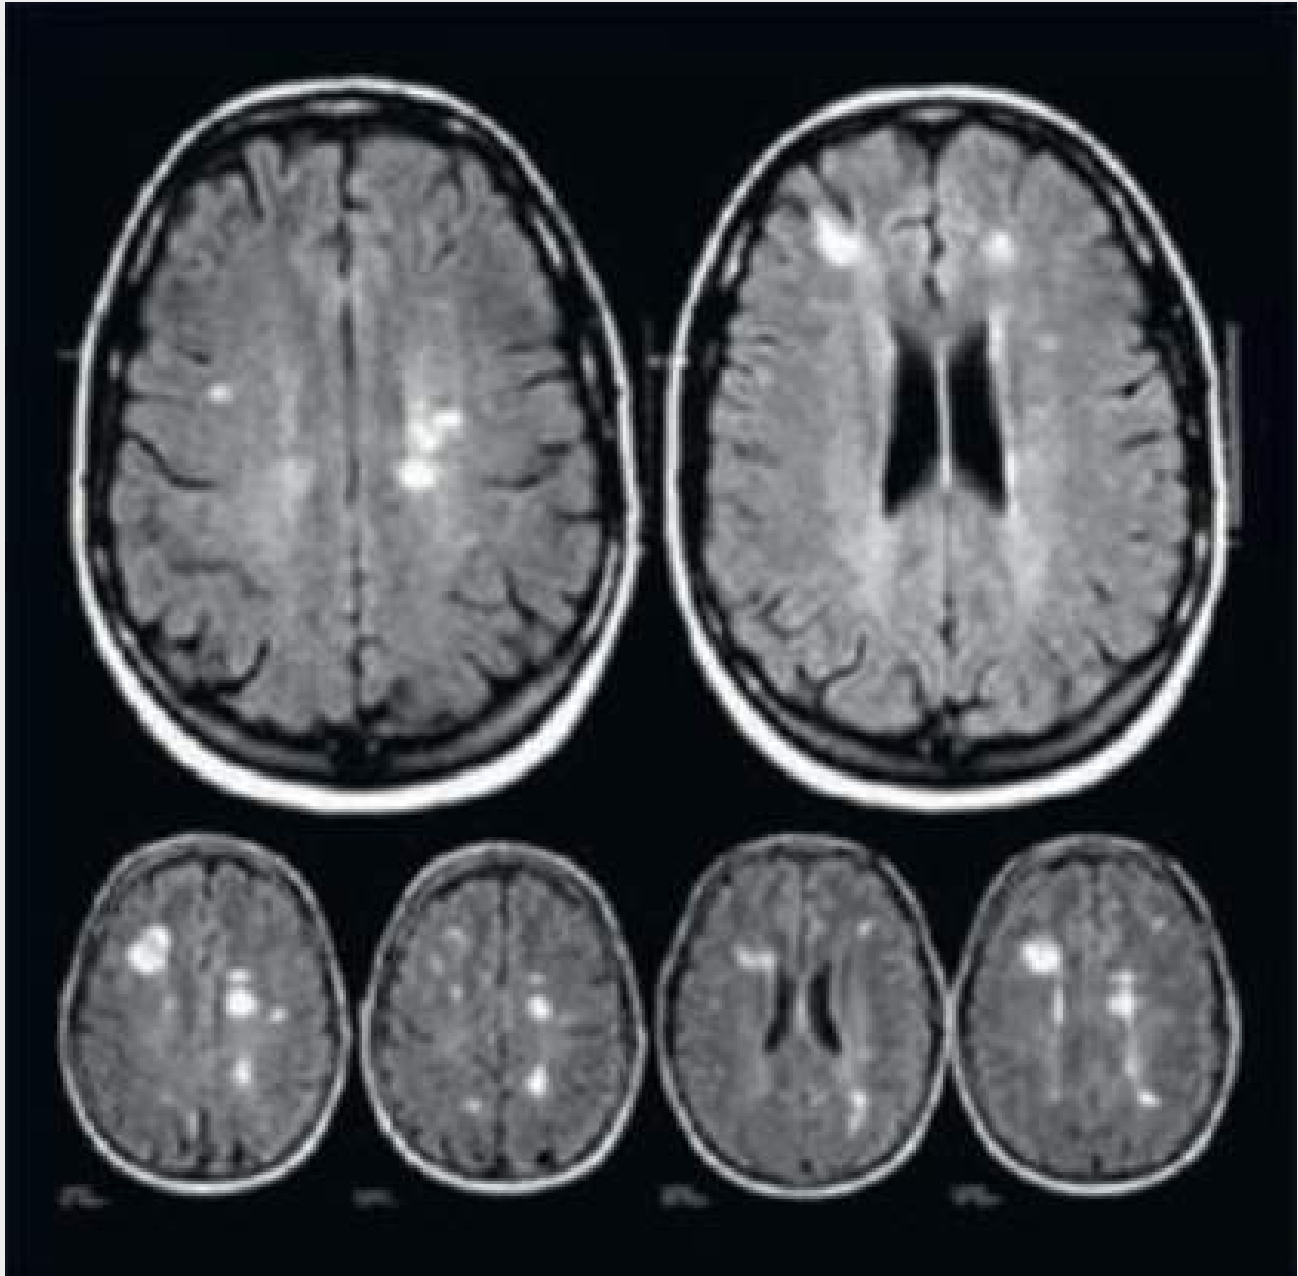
Typical findings on diffusion-weighted MRI after transcatheter aortic valve replacement (TAVR) showing multiple embolic lesions.
